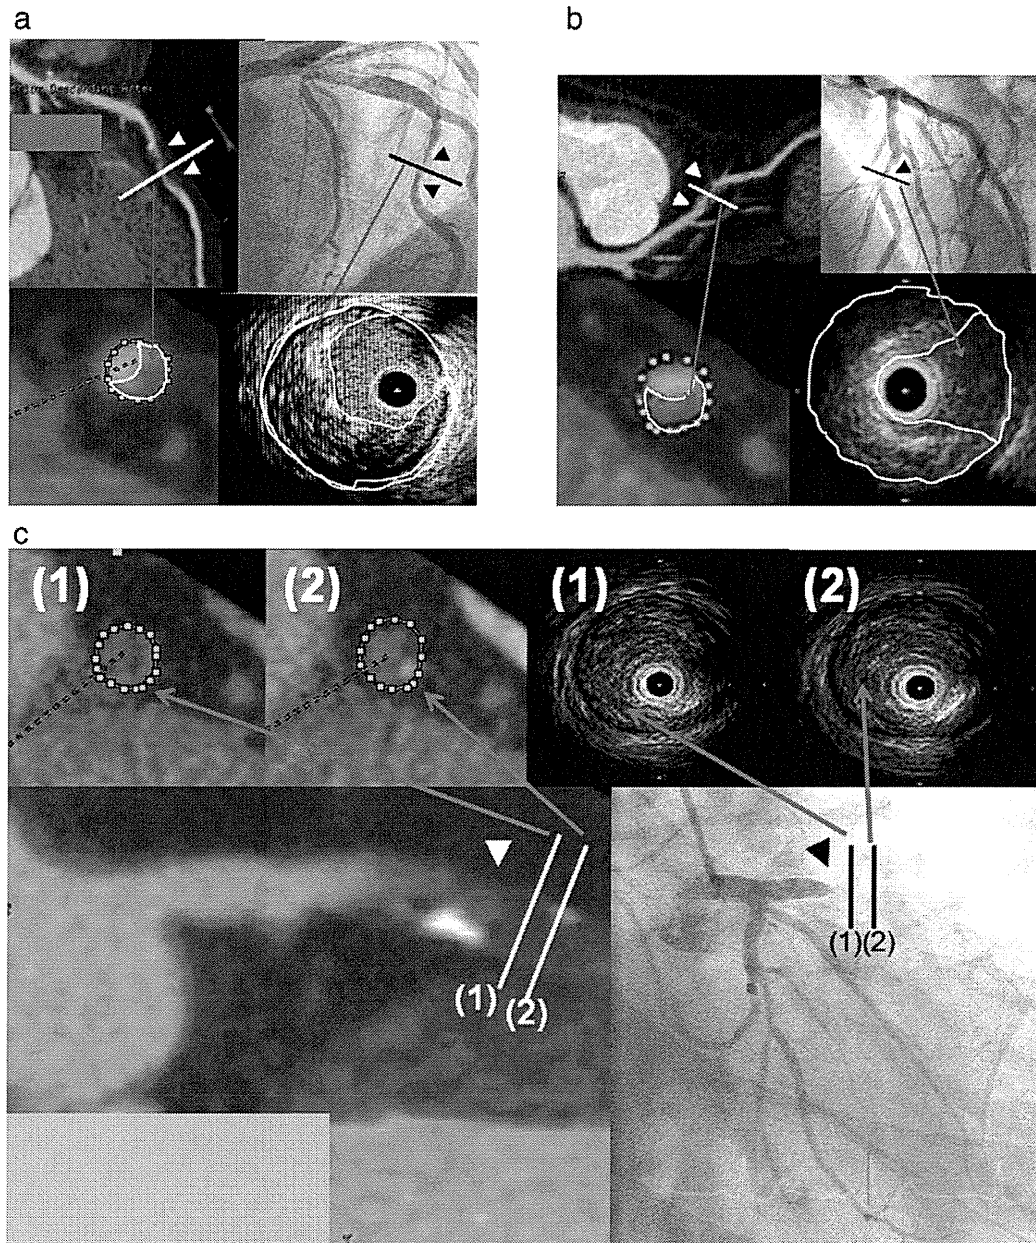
Typical images of each type of plaque by intravascular ultrasound (IVUS) and corresponding multislice computed tomographic (CT) images with conventional coronary angiogram (CAG). a. Typical CT images (left upper and lower figures) of soft plaques identified by IVUS (right lower figure) acquired from a 76 year old male. Curved planar reformation images of left anterior descending branch (LAD) (left upper figure) revealed significant stenosis with non calcified plaques (white arrow heads) in the middle portion of LAD; short axis images of coronary arteries (left lower figure) were made perpendicular to the long axis of LAD (white bar in left upper figure) in which low CT area (average 36 HU, surrounded by white circle) occupied more than 50% of cross sectional area (CSA) of the coronary arterial lumen (surrounded by green dots). CAG (right upper figure) also revealed significant stenosis in the middle portion of LAD (black arrow heads), and at the corresponding site of the black bar in CAG, soft plaque could be observed in IVUS (right lower figure). Considering the distance from the ostium and presence of the side branch etc. as the landmark of the location of the plaques, we concluded that the soft plaques in IVUS (right lower figure) correspond to the non-calcified plaques in short axis images of coronary arteries in CT (left lower figure). b. Typical CT images (left upper and lower figures) of fibrotic plaques identified by IVUS (right lower figure) acquired from a 41 year old male. Curved planar reformation images of LAD (left upper figure) revealed significant stenosis with non-calcified plaques (white arrow heads) in the middle portion of LAD; short axis images of coronary arteries (left lower figure) were made perpendicular to the long axis of LAD (white bar in left upper figure) in which low CT area (average 88 HU, surrounded by white circle) occupied more than 50% of CSA of coronary arterial lumen surrounded by green dots. CAG (right upper figure) also revealed significant stenosis in the middle portion of LAD (black arrow head) and at the corresponding site of the black bar in CAG, fibrotic plaque can be observed in IVUS (right lower figure). Considering the distance from the ostium and presence of the side branch etc. as the landmark of the location of the plaques, we concluded that the fibrotic plaques in IVUS (right lower figure) correspond to the non-calcified plaques in short axis images of coronary arteries in CT (left lower image). c. Typical images of thrombi by IVUS and corresponding CT images. Thrombi were observed in the proximal LAD in IVUS in a 65 year old male and at the corresponding site in CT. Typical CT images (left figures) of thrombi identified by IVUS (right upper figures) acquired from a 65 year old male. Curved planar reformation images of LAD (left upper figure) revealed complete occlusion with low CT area (white arrow head) with spotty calcified plaques in the proximal portion of LAD; short axis images of coronary arteries (left upper figures) were made perpendicular to the long axis of LAD (white bar (1) and (2) in left lower figure) in which low CT area (average 49 HU) occupied 100% of CSA of coronary arterial lumen surrounded by green dots. CAG (right lower figure) also revealed complete occlusion in proximal portion of LAD (black arrow head) and at the corresponding site of the black bar in CAG, movable thrombi could be observed in IVUS (right upper figures). Considering the distance from the ostium and presence of the side branch etc. as the landmark of the location of the plaques, we concluded that the thrombi in IVUS (right upper figures) correspond to the low CT area in short axis images of coronary arteries in CT (left lower image).
